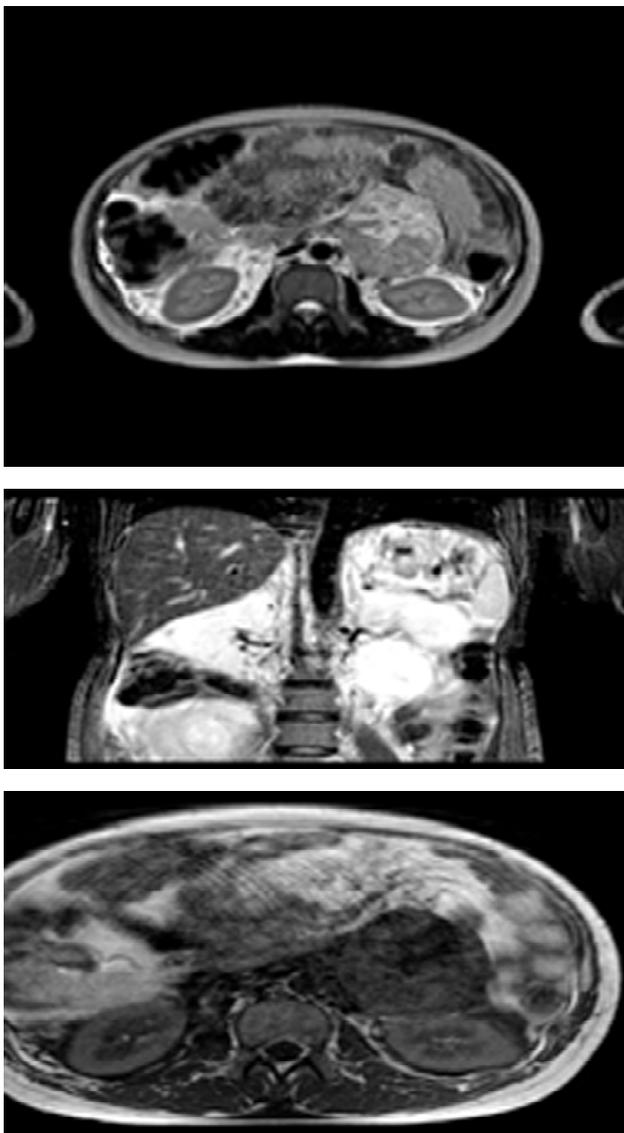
MRI abdomen and pelvis.
